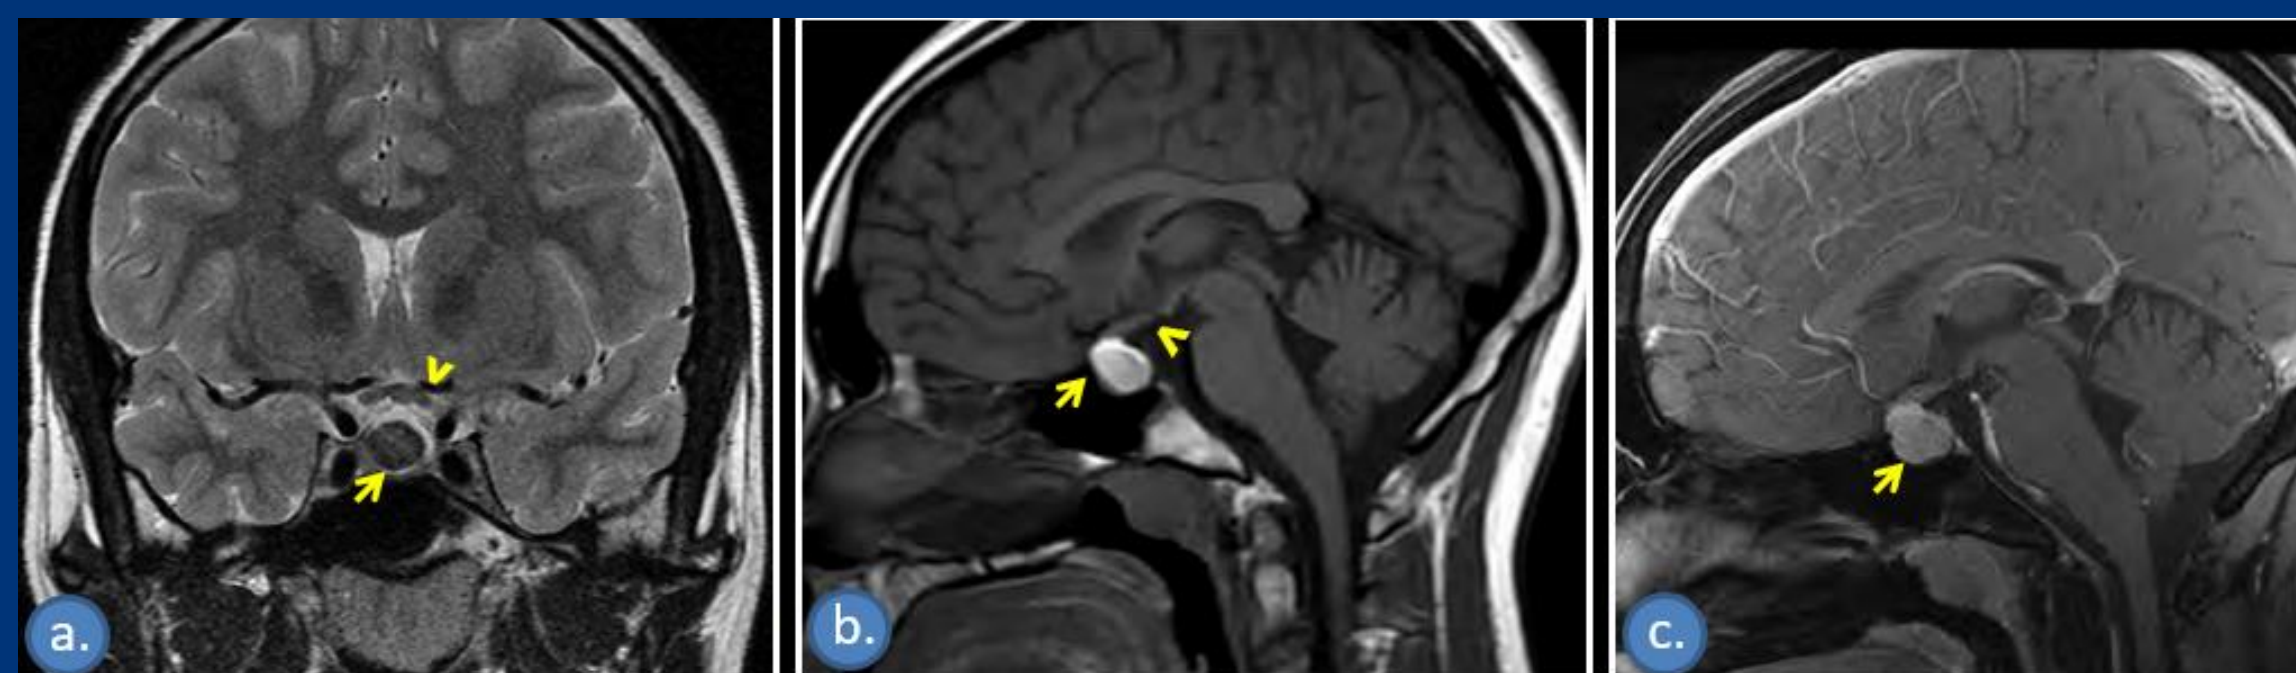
MRI Brain without and with IV contrast. a. Coronal T2-weighted, shows a hypointense and large circumscribed mass in the pituitary gland (arrow), slight upward lifting of the optic chiasma (^). b and c. Sagittal T1-weighted without and with contrast respectively, the pituitary mass is homogeneously hyperintense (arrow) without significant enhancement.
